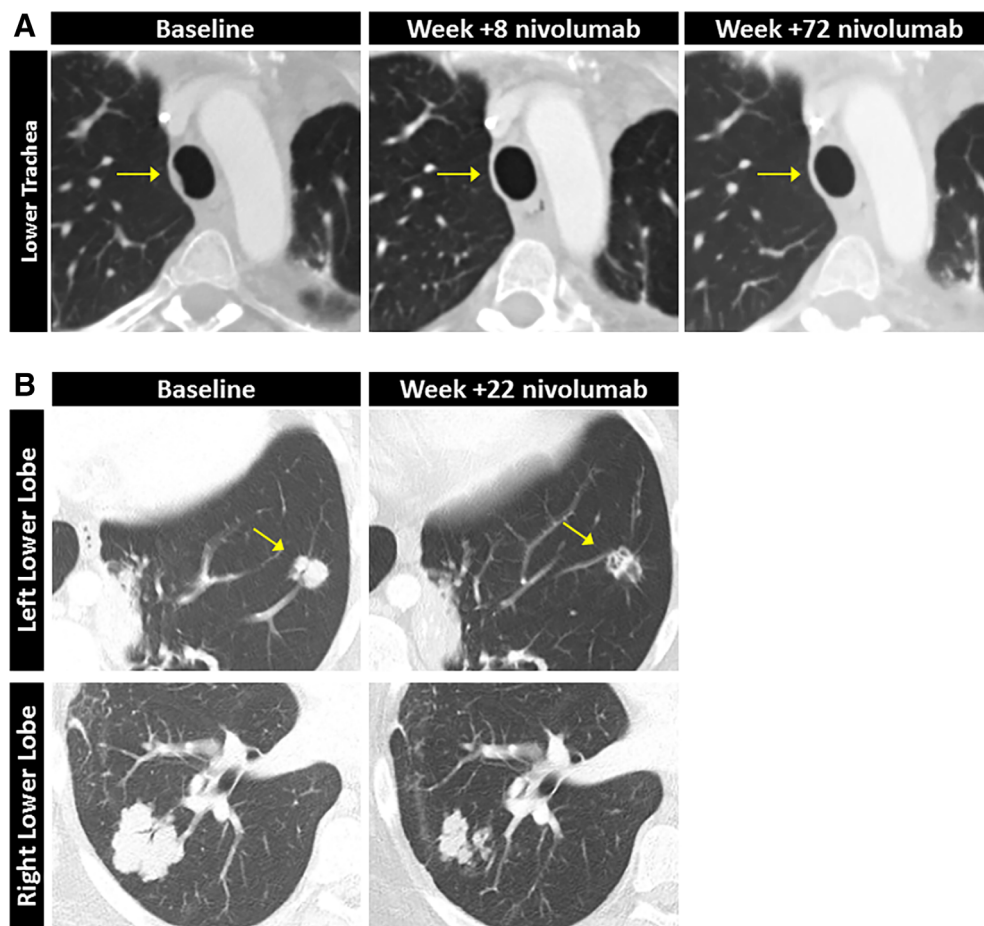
Pre- and posttreatment computed tomography (CT) images of Patients 1 and 2. (A): Pre- and posttreatment CT axial images of Patient 1 showing improvement of a faintly visible squamous papilloma in distal trachea. (B): Pre- and posttreatment CT axial images of Patient 2 showing improvement of parenchymal lung papillomas consisting of biopsy-confirmed recurrent respiratory papillomatosis.
